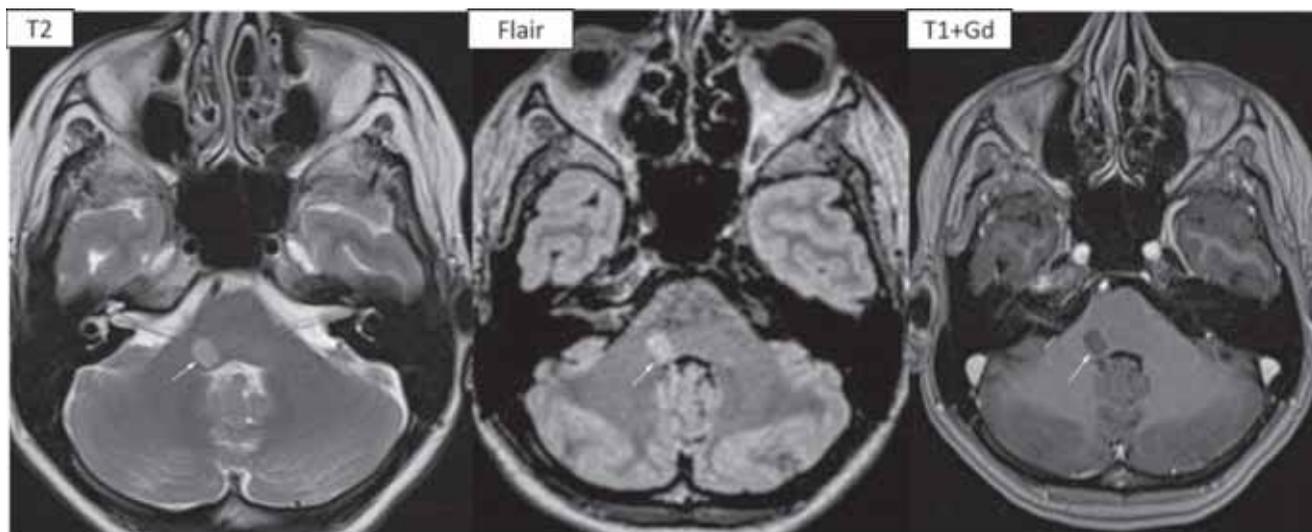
Axial images revealing hyperintense lesion on T2 and FLAIR and hypointense non-enhancing on T1+Gd, located in the right middle cerebellar peduncle
